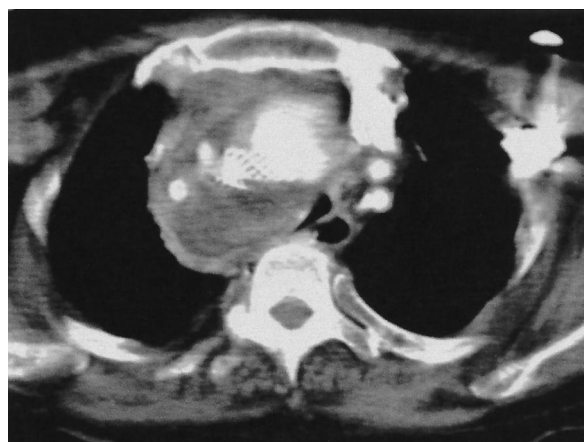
CT scan of chest reveals large, ill-defined homogeneous mass measuring 5 × 3 cm adjacent to right brachiocephalic artery stent descending into anterior mediastinum consistent with mycotic aneurysm with surrounding hematoma.
